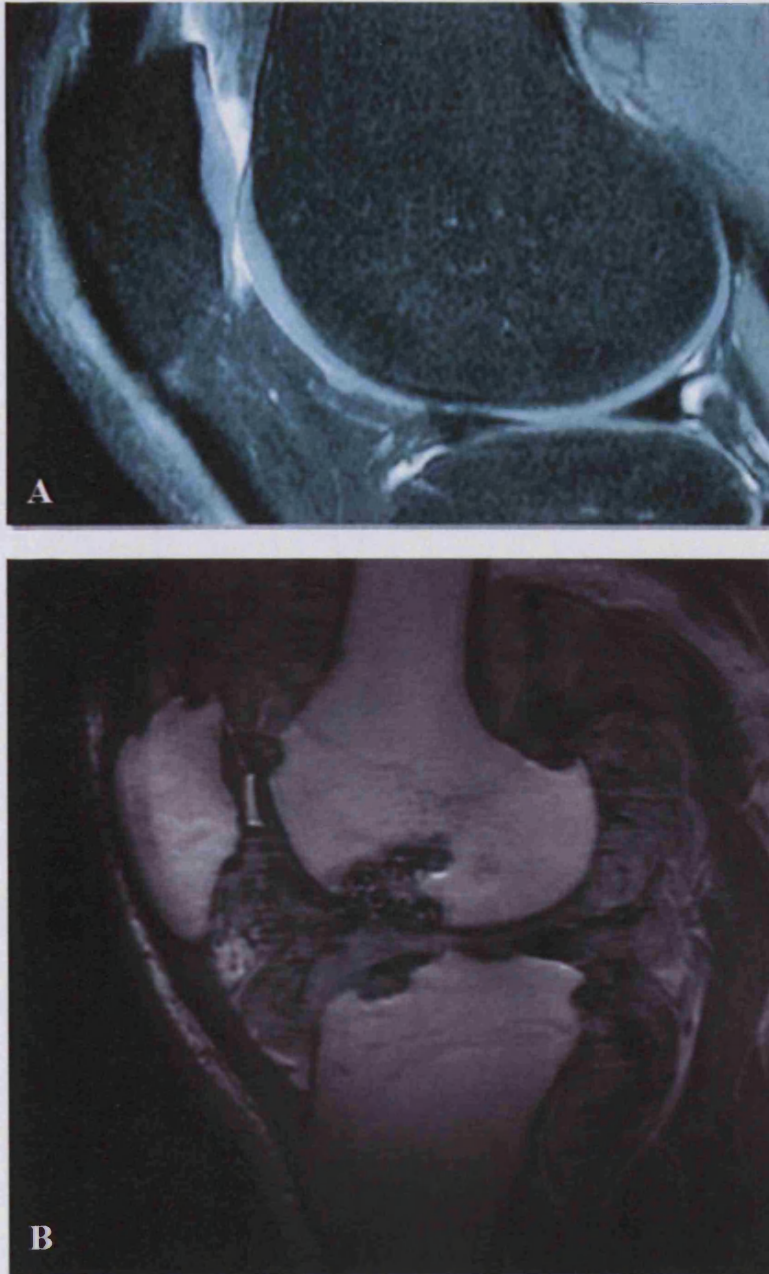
Images of the knee joint, taken using Magnetic Resonance Imaging (MRI). A- A healthy knee joint. The articular cartilage can be seen clearly, protecting the ends of the long bones (image from www.kneeclinic.info/knee_imaging.php) B- A knee joint requiring total knee replacement due to the severe degradation of the articular cartilage, symptomatic of end-stage osteoarthritis (image used with kind permission of Dr. Hechmi Toumi, Department of Orthopedics, Llandough Hospital, Penlan Road, Llandough. CF64 2XX.).
